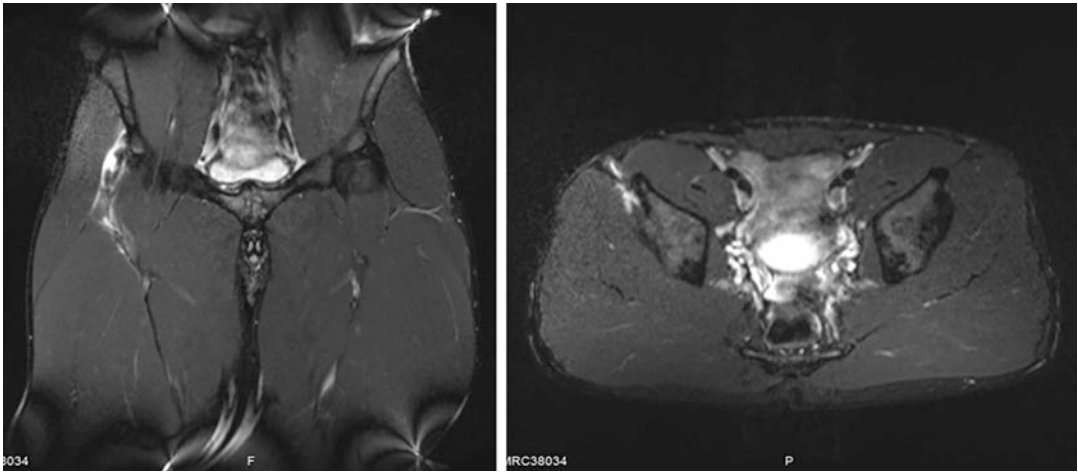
MRI views of proximal rectus femoris avulsion
